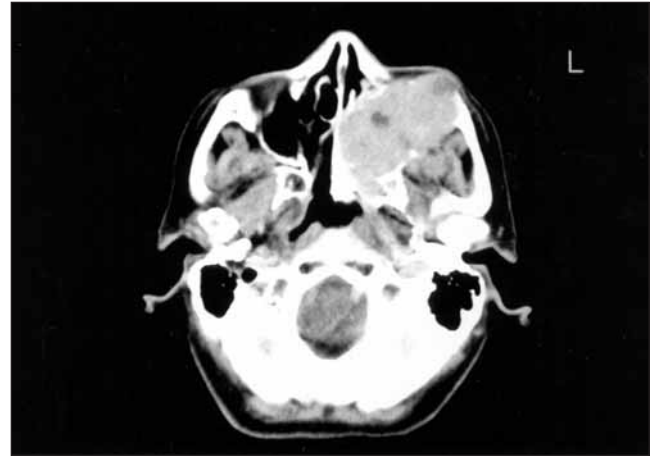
Axial CT showed that the mass had cystic areas with an extension to premaxillary skin.
